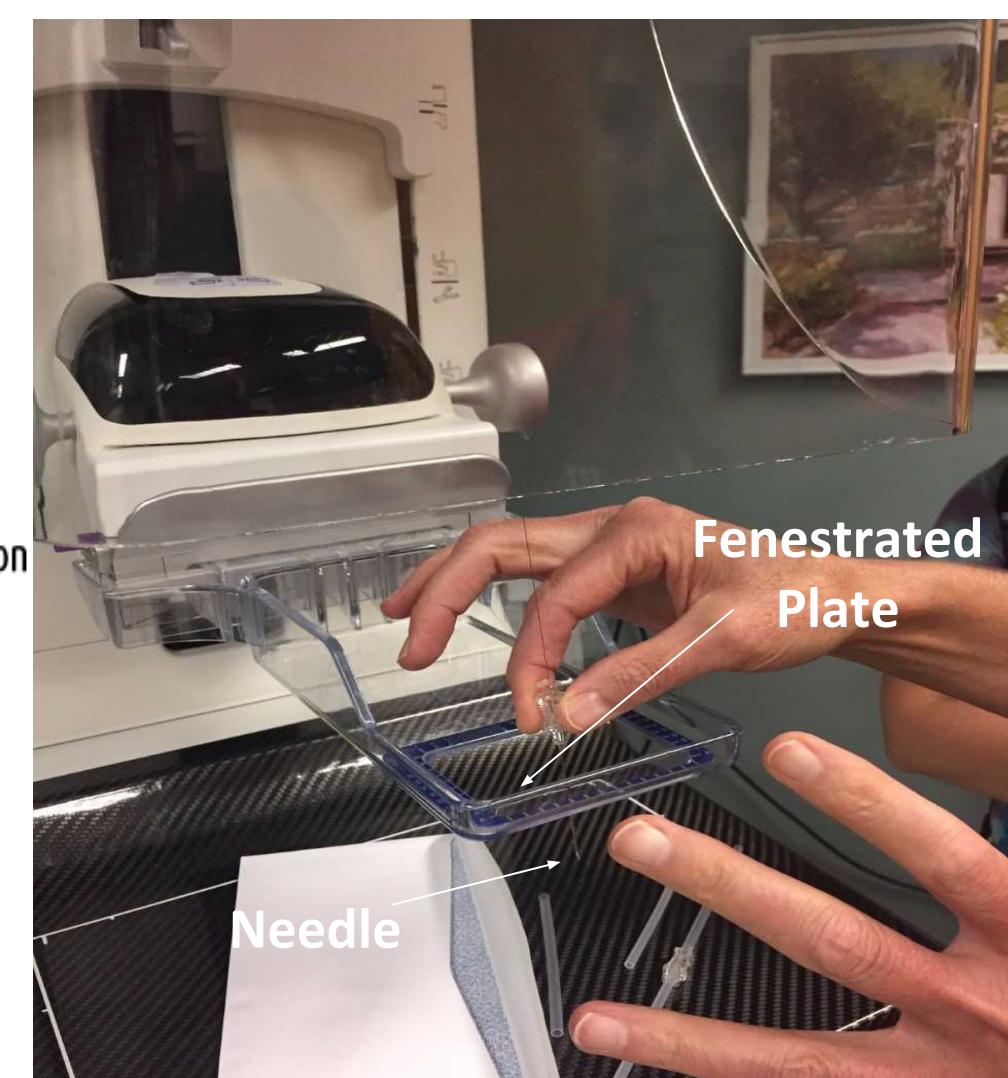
Needle insertion through fenestrated plate. The X-ray beam and light are directly above.
